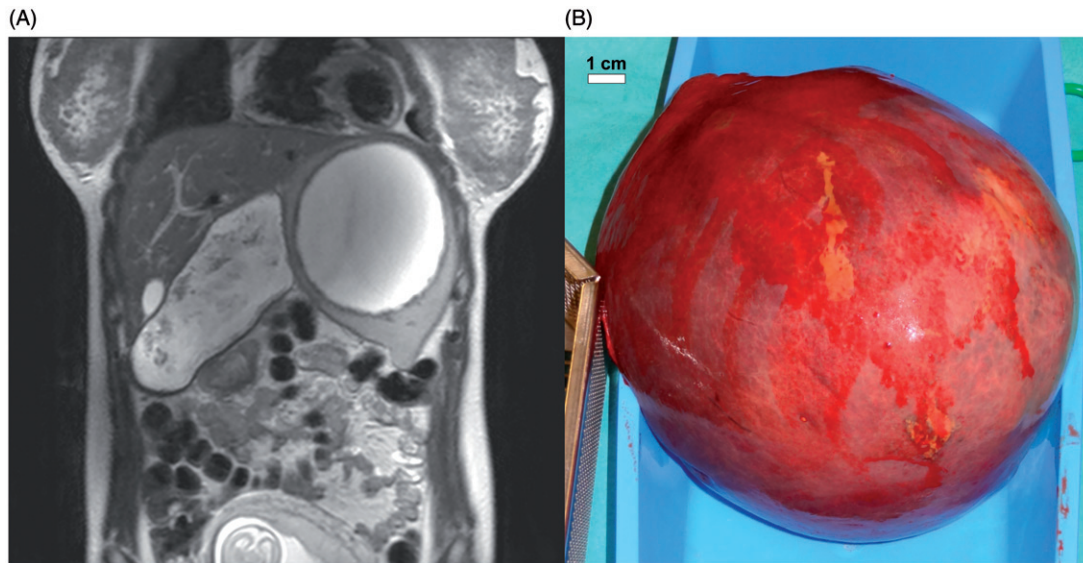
(A) MRI scan showing the splenic cyst with gravid uterus at the end of the first trimester of pregnancy. (B) Splenectomy at 6 months postpartum.
